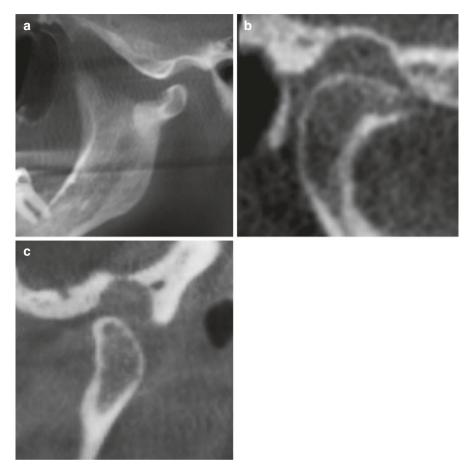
CBCT reformats of some of the differential diagnoses for inferior condylar position: (a) condylar fracture, (b) osteochondroma (similar to an osteophyte but displaces condylar out of the fossa), and (c) space-occupying masses in the joint space (the mass itself may not be visualized radiographically, but if it is large enough its effect on the fossa and condyle will) (Courtesy, M. Bourgeois, DDS)
